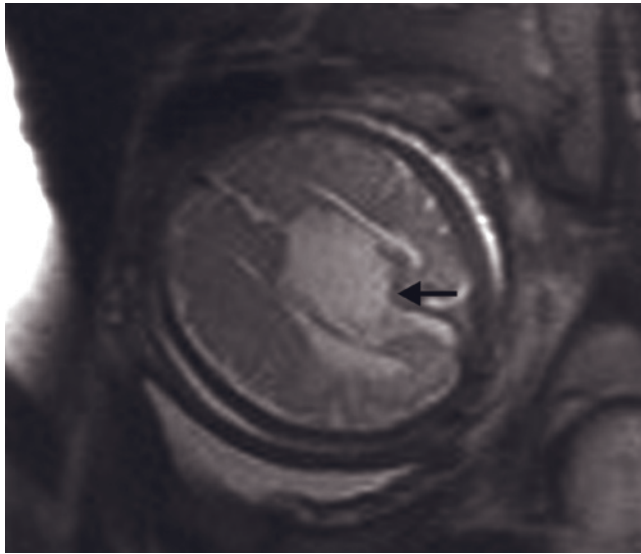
Normal corpus callosum and absent corpus callosum at 22 weeks of gestation. Transverse (*a*) and coronal (*b*) T2-weighted SS-ETSE images through a normal fetal brain at 22 weeks of gestational age. The lateral ventricles are normal in size (arrowheads, *a*) with a normal intervening distance, and there is a visible corpus callosum (arrow, *b*). Transverse (*c*) and coronal (*d*) T2-weighted SS-ETSE images through a different fetal brain at 22 weeks of gestational age. There is dilatation and increased distance between the lateral ventricles (arrowheads, *c*) and absence of connecting fibers between the cerebral hemispheres (arrow, *d*).
